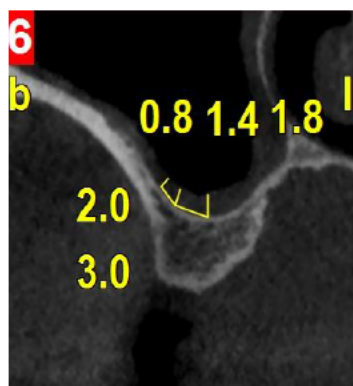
CBCT analysis and calculation of the average mucosal thickness in the cross-sectional image.
